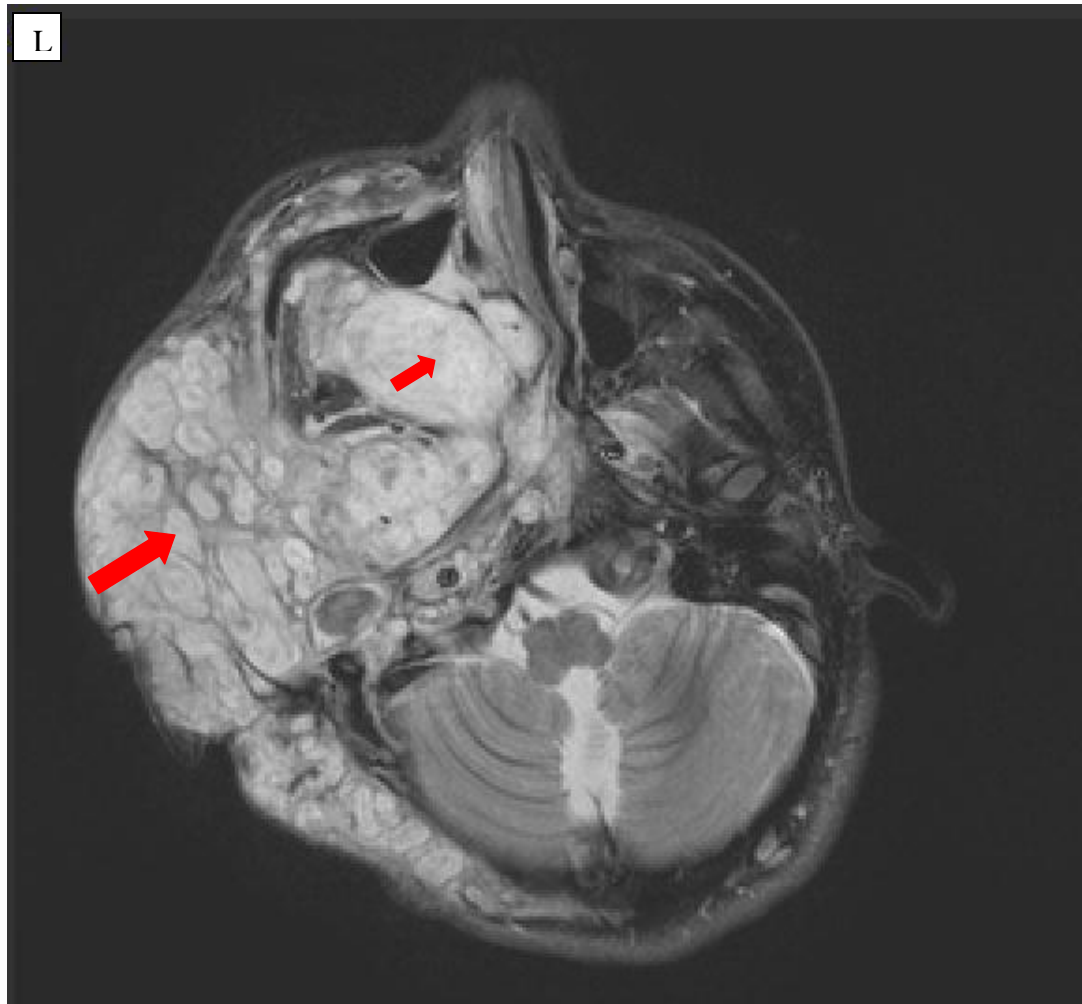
MRI scan (axial view) facial plexiform neurofibroma with stenotic left ear canal (L) (NF1 Individual Code 026).
